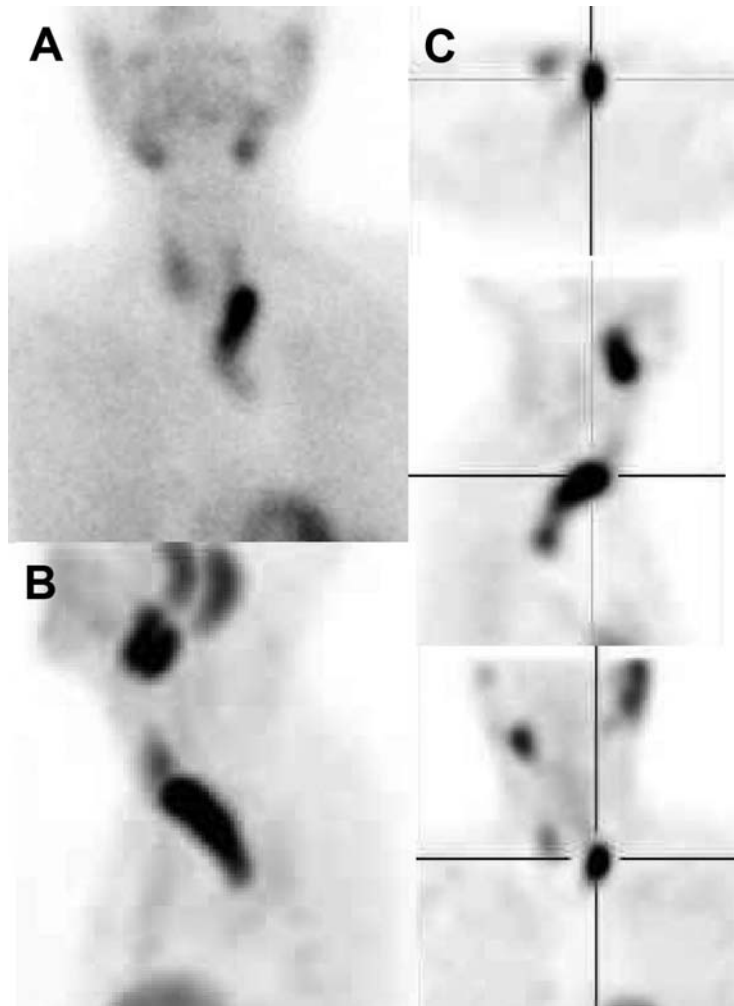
The ^{99m}Tc -sestamibi scintigraphy shows a left large parathyroid adenoma extending into the mediastinum. (A) Planar anterior image at 45 min postinjection. (B) 3D image of SPECT acquisition. (C) Orthogonal views (axial, sagittal, and coronal) of SPECT.
